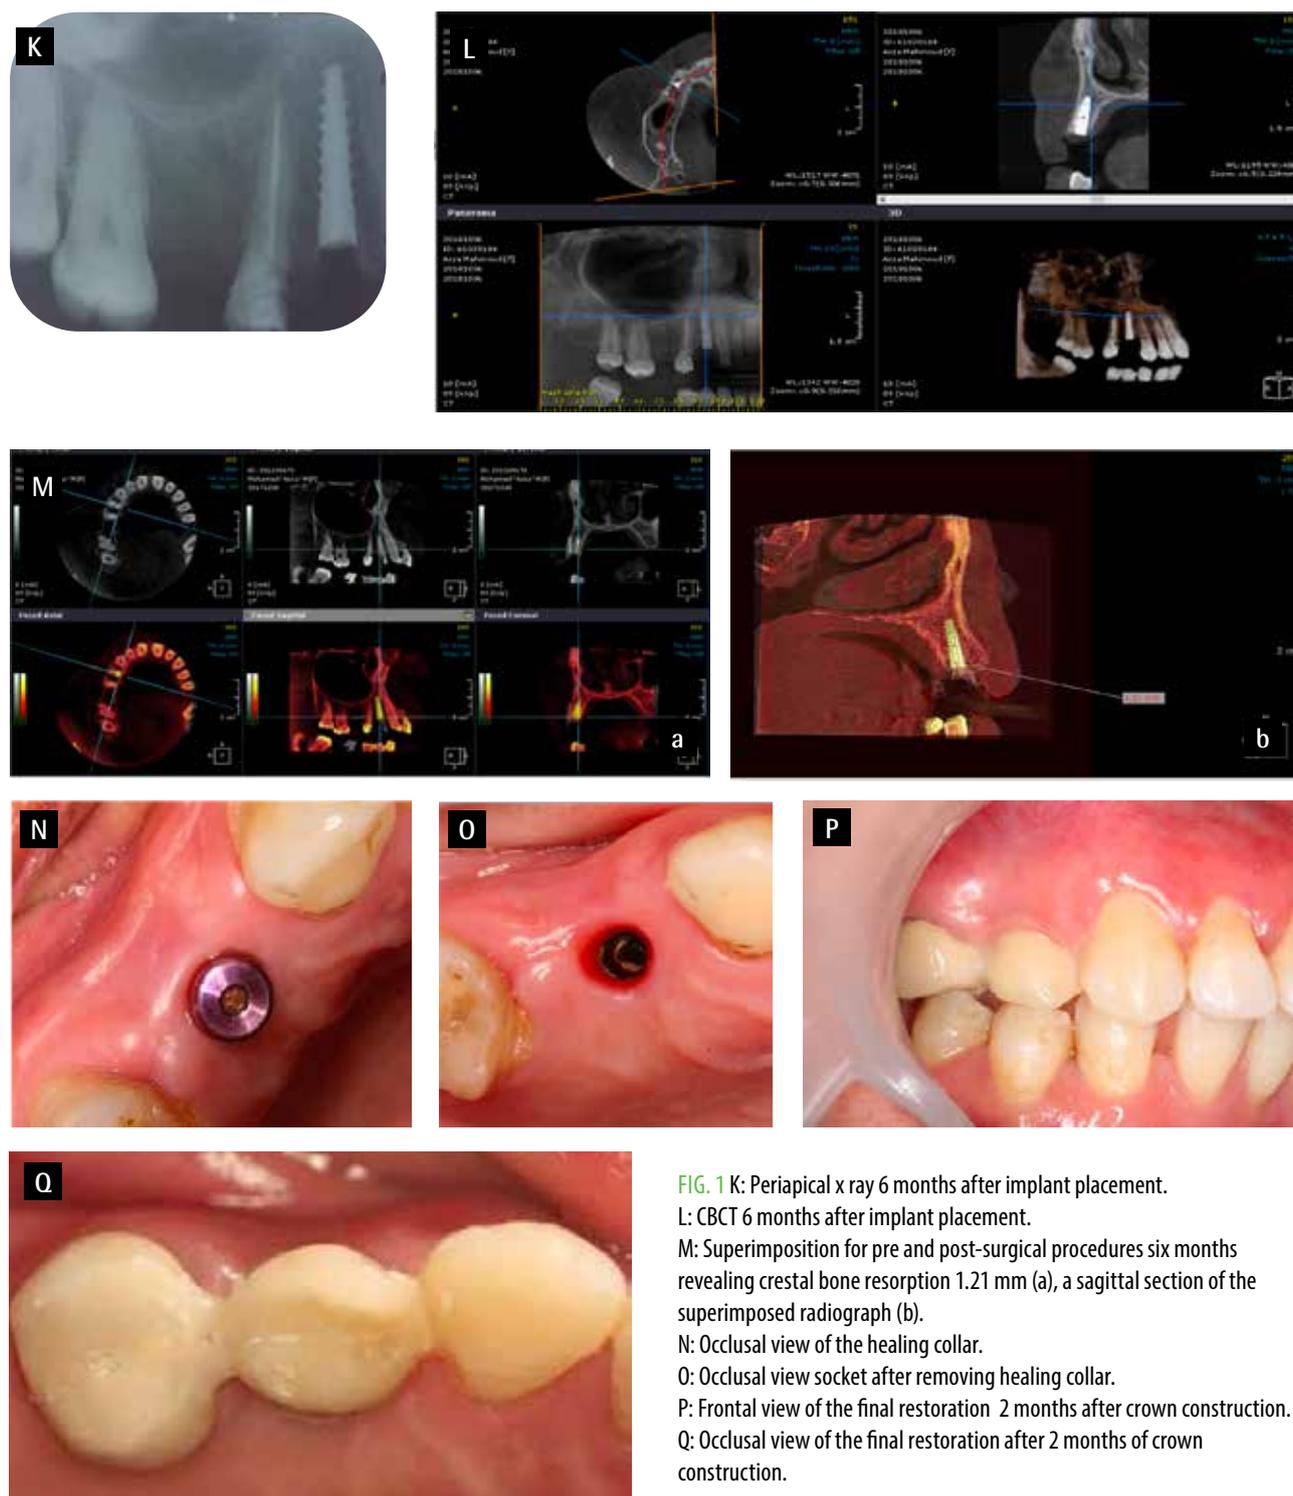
K: Periapical x ray 6 months after implant placement.
